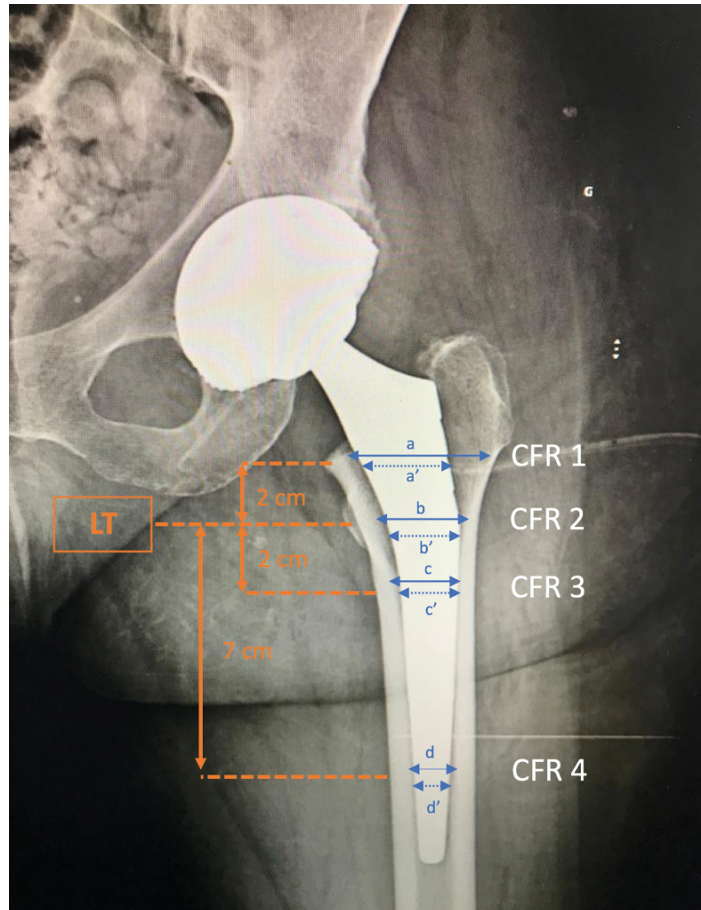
Implant size was measured on the x-rays using the canal fill ratio (CFR) at four different points on the postoperative x-ray: the lesser trochanter, 2cm above and below the lesser trochanter, and 7cm below the lesser trochanter.
